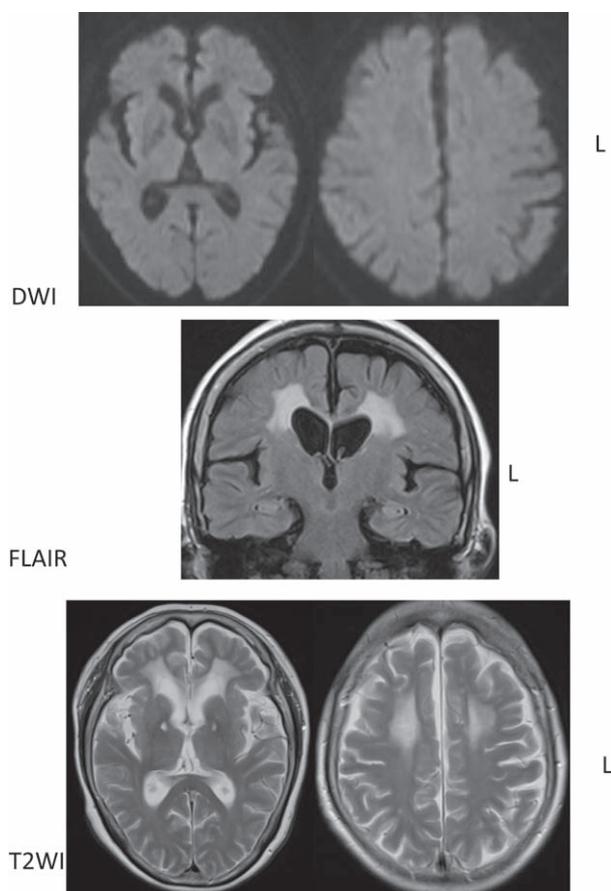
Brain MRI findings for case 2, 6 months after the onset. Unlike in case 1, the bilateral, high-intensity lesions in the cerebral white matter could still be detected on FLAIR image and the T2WI, but not on DWI. Additional characteristics of acute carbon monoxide poisoning, such as necrosis in the globus pallidi, was observed on the T2WI. DWI=diffusion-weighted image, FLAIR=fluid-attenuated inversion recovery, MRI=magnetic resonance imaging, T2WI=T2-weighted image.
